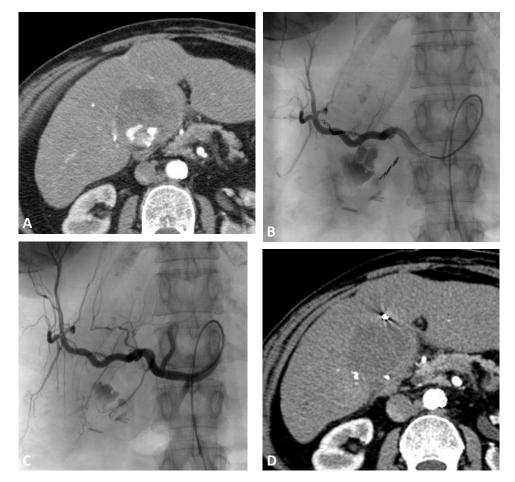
Early (A) arterial phase CT imaging demonstrates active arterial intra-tumoral hemorrhage in the segment IVB hepatocellular carcinoma, as well as residual enhancement along the periphery of the treated tumor bed, six weeks following initial DEB-TACE. Digital subtraction angiography (DSA) of the right hepatic artery following repeat DEB-TACE and placement of 3mm .018" VortX microcoils (Boston Scientific, Quincy, MA, USA) into two arteries supplying the segment V hepatocellular carcinoma (B) demonstrates no further extravasation of contrast (C). 9 month follow up CT (D) demonstrates no residual enhancing tumor or extravasation of contrast, compatible with successfully treated hepatocellular carcinoma.
